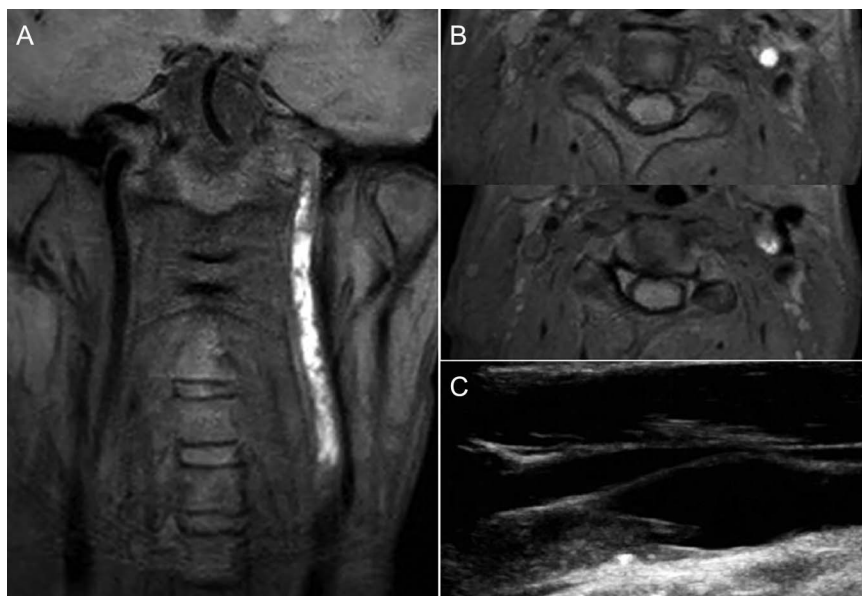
Patient number 20 with a left internal carotid artery dissection. (A) Coronal of three-dimensional (3D) T1 volumetric isotropic turbo spin echo acquisition (VISTA) image shows hyperintensity of the left internal carotid artery at 26 days of onset. (B) Axial reconstructions of 3D T1 VISTA images show the occluded left internal carotid artery without typical crescent-like hyperintensity. (C) Ultrasound of the left internal carotid artery at 15 days of onset shows a double lumen and intima.
